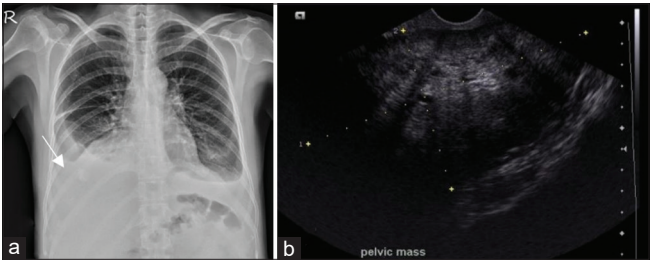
Chest X-ray revealed blunting of bilateral costophrenic angles which was more dominant on the right side (arrow) (a): transvaginal sonography revealed a hyperechoic mass lesion over cul-de-sac (yellow dotted line) (b)
